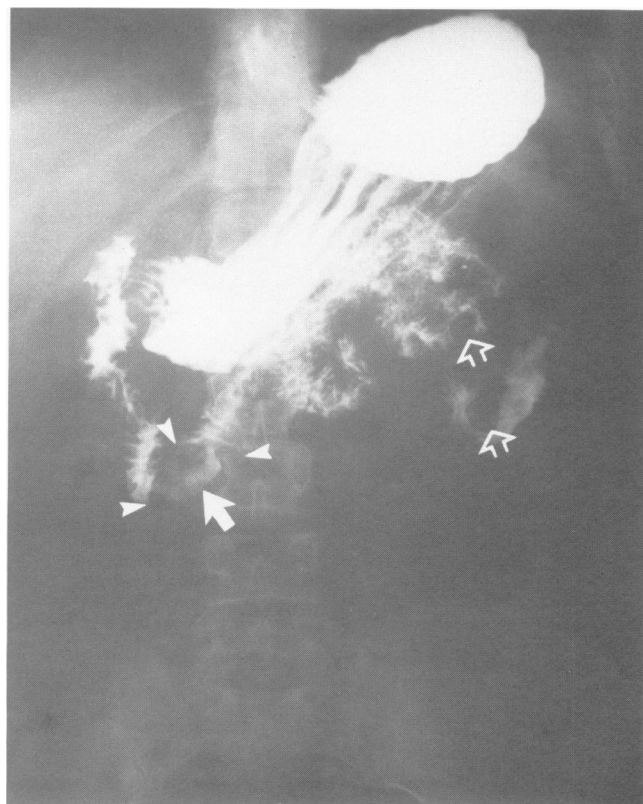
Upper gastrointestinal x-ray demonstrates a round mass in the third part of duodenum (small solid arrows) containing a central ulcer (large solid arrow). Multiple filling defects (large open arrows) also are shown.
